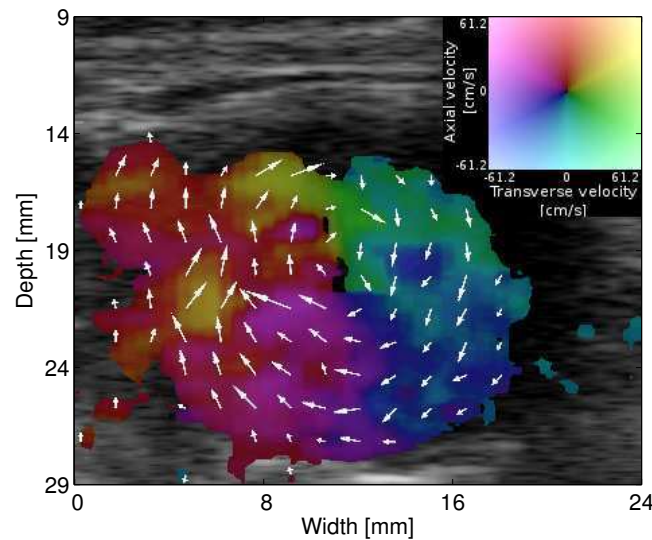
Real-time, *in vivo* TO ultrasound image of the abdominal aorta in the transverse plane. The vector velocity color map is shown in the upper right corner.
